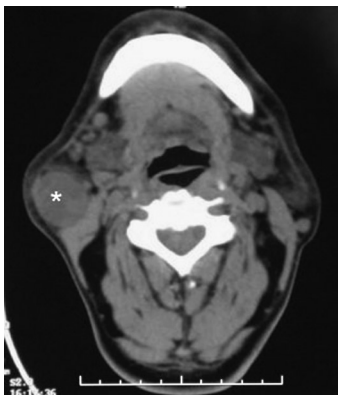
A computed tomographic scan shows that an oval semisolid lesion with a well-defined border (asterisk) is just inferior to the right parotid gland. It had both cystic and solid components.
